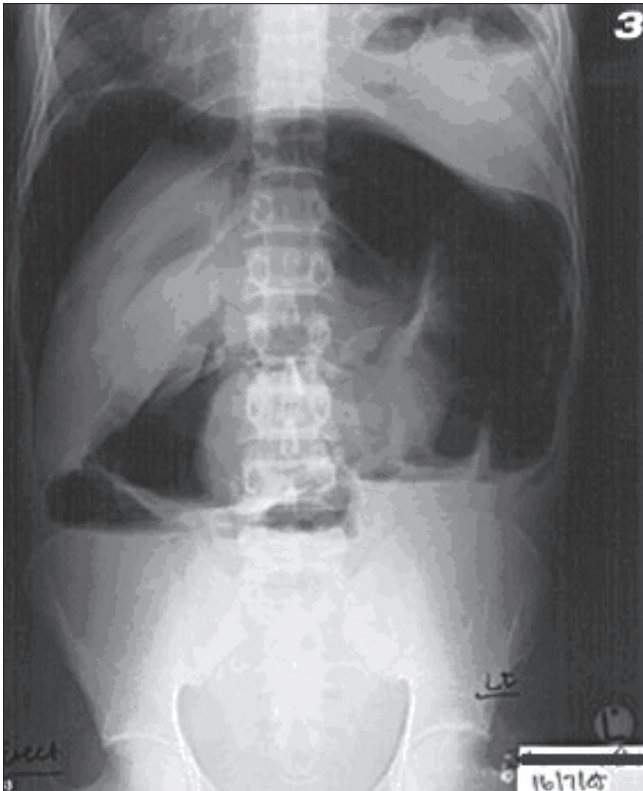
Erect abdominal radiograph, demonstrating gross volumes of free air.
